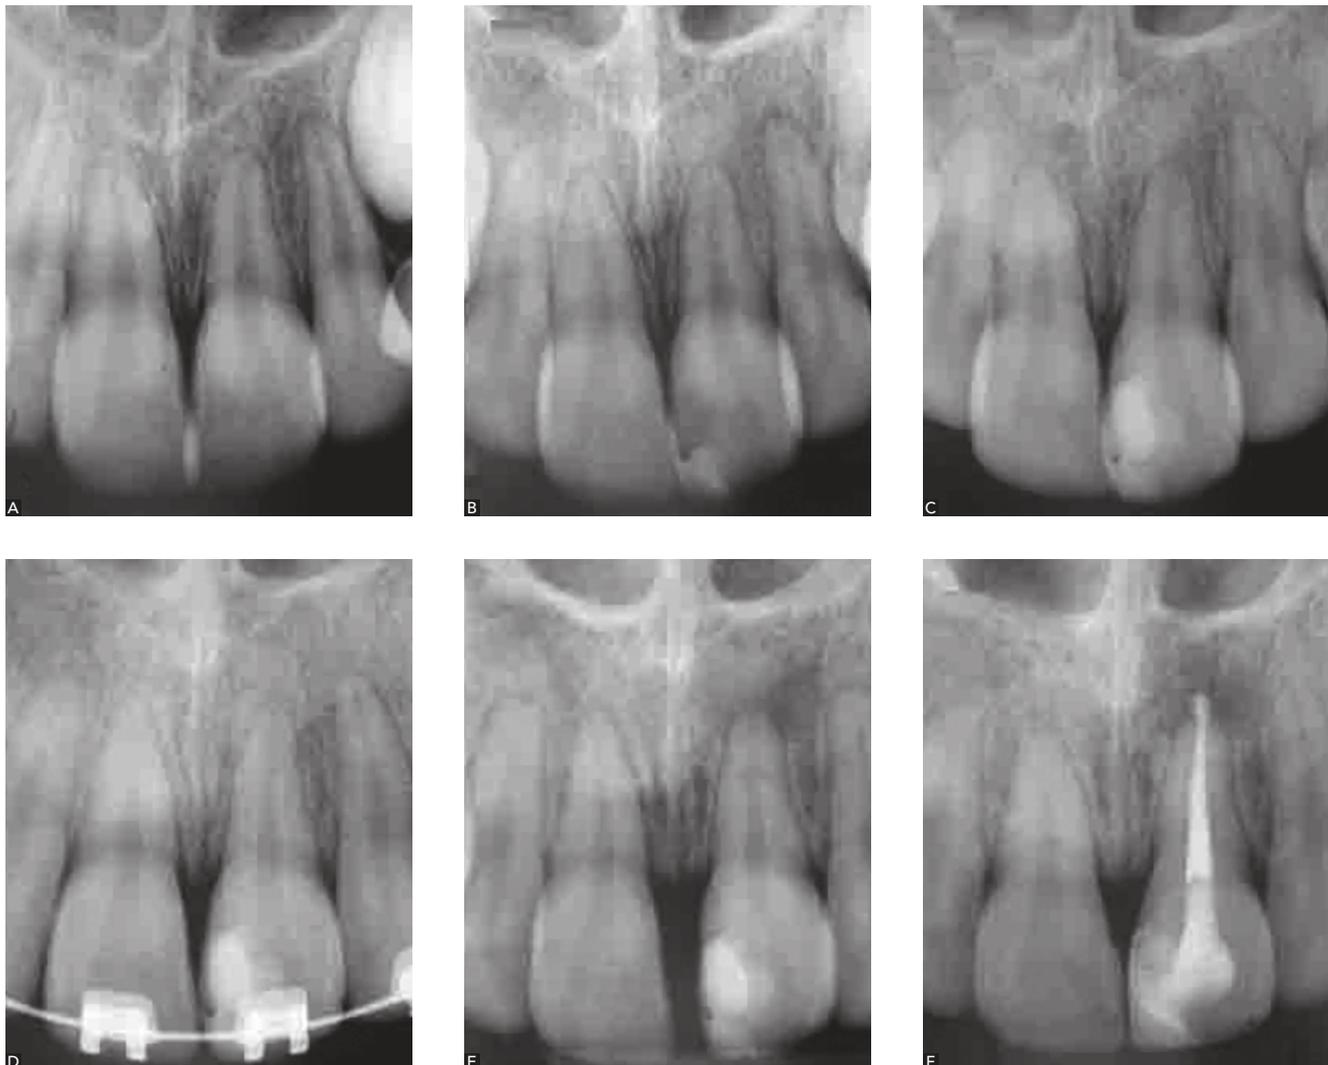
Radiographic sequence of maxillary central incisors with short root anomaly (SRA). A) Mixed dentition indicating early stages of SRA; B) before, C) during and D, E, F) after orthodontic movement, showing relative control of external apical root resorption .
